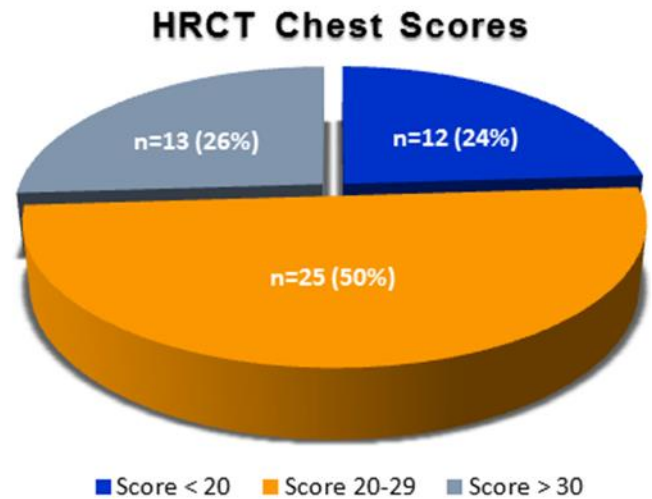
HRCT Severity scores of COVID-19 Pneumonia cases that received Tocilizumab.
